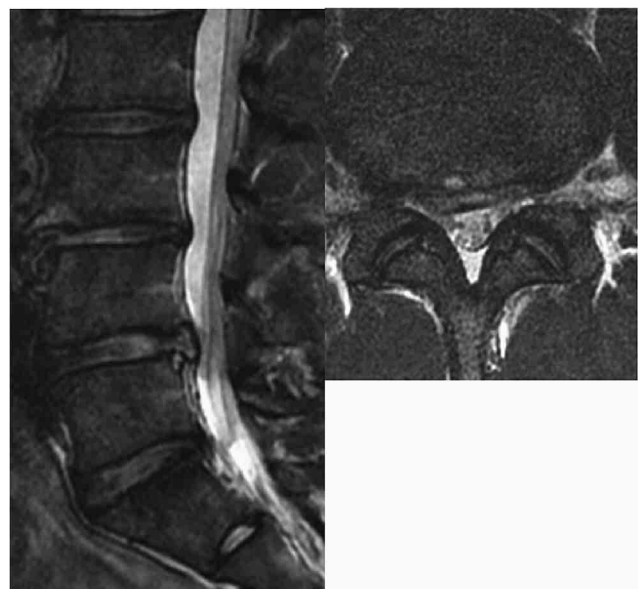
MRI (T2-weighted sagittal and axial view at L4/5 level) after repeat PED. The HNP was removed by PED using a transforaminal approach.
